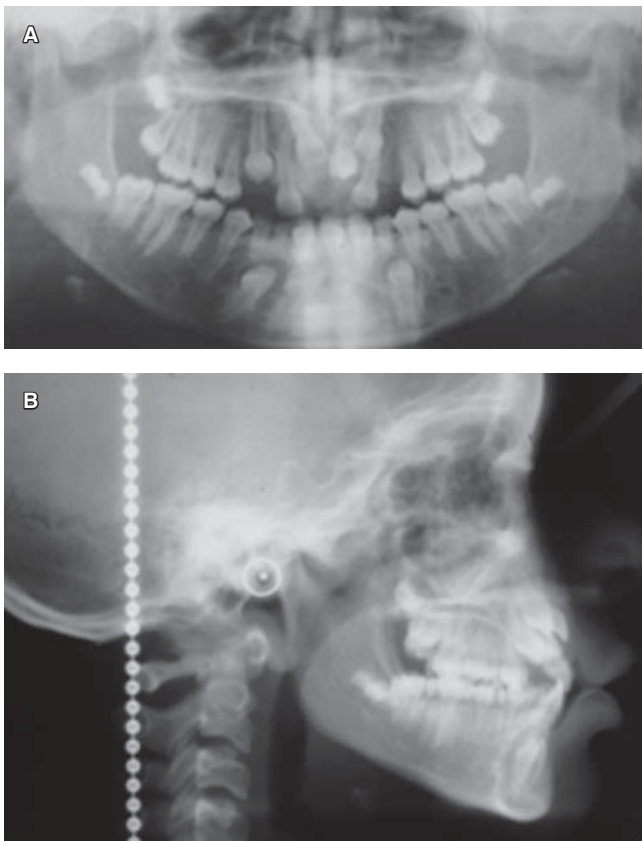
Pretreatment radiographs. A corresponds to the panoramic radiograph and B to the lateral headfilm.
